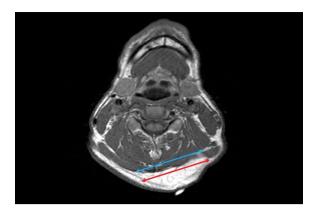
The tumor touches the underlying structures broadly. Axial T1-weighted MRI shows a lipoma in the back of the neck. This case belongs to the "broadly touching" category since the ratio of the maximum tumor diameter (red two-headed arrow, 67 mm) to the tumor base length that touches the underlying structures (blue two-headed arrow, 67 mm) is 1.0 and therefore greater than the 0.8 threshold
